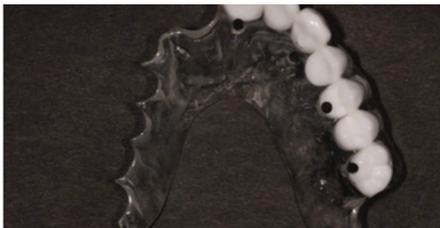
Radiographic stent with radiopaque Voclar teeth
